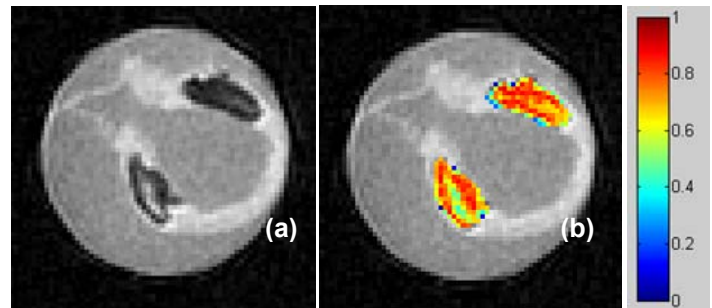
MR image (a) and the corresponding calcification map (b) obtained from serial UTE images; the colorbar shows the calcification fraction. Note the level of continuity on the colored calcification maps.
